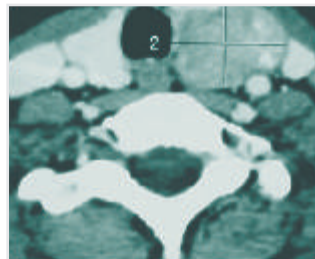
CT scan showing tumour from left lobe of thyroid
